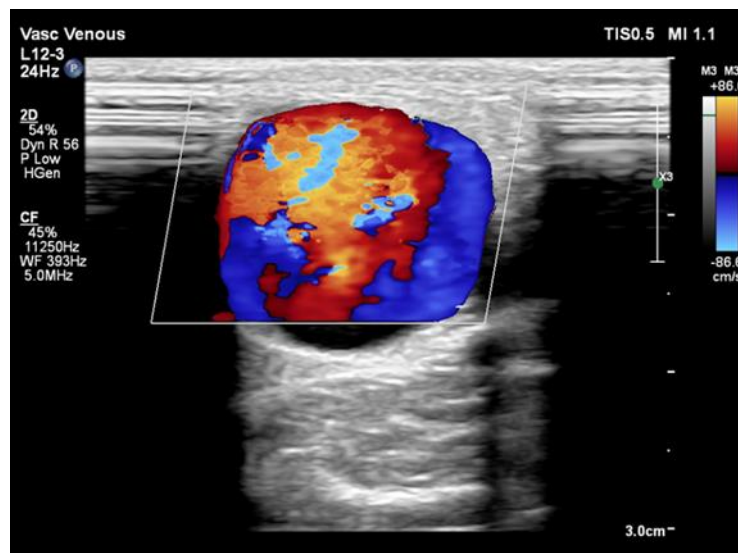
Colour Doppler ultrasound showing pseudoaneurysm formation with a classic “YIN YANG” pattern.
